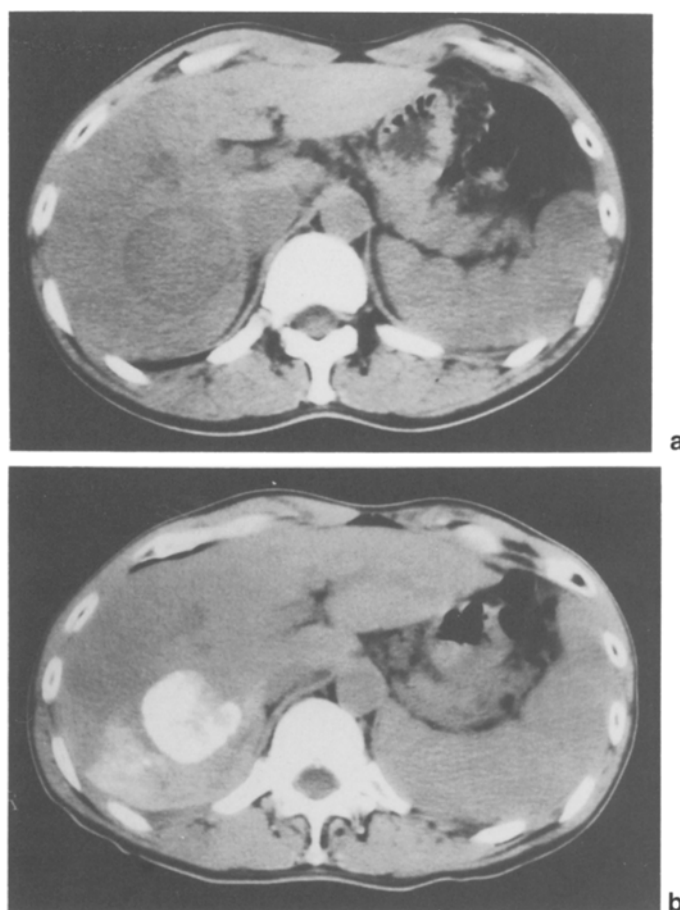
Abdominal CT-scan findings of a resectable patient with HCC before and after TIE therapy. a A CT scan showing a low-density area in the right hepatic lobe before TIE. b A CT scan showing that the space-occupying lesion has changed to a high-density area due to Lipiodol accumulation on day 5 after TIE
